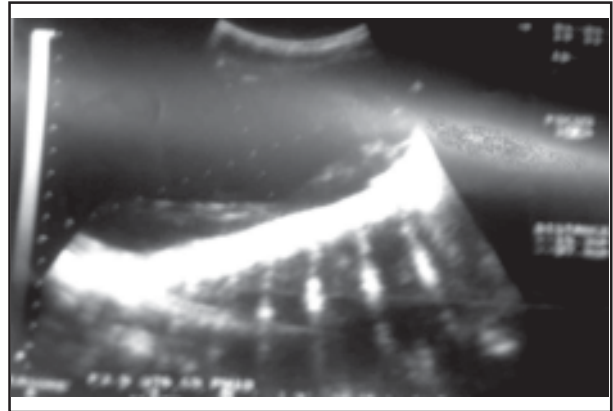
An abdominal ultrasound scan of patient showed single cyst, 155x75 mm in size, including hypoechoic debris in the right lobe of liver.
